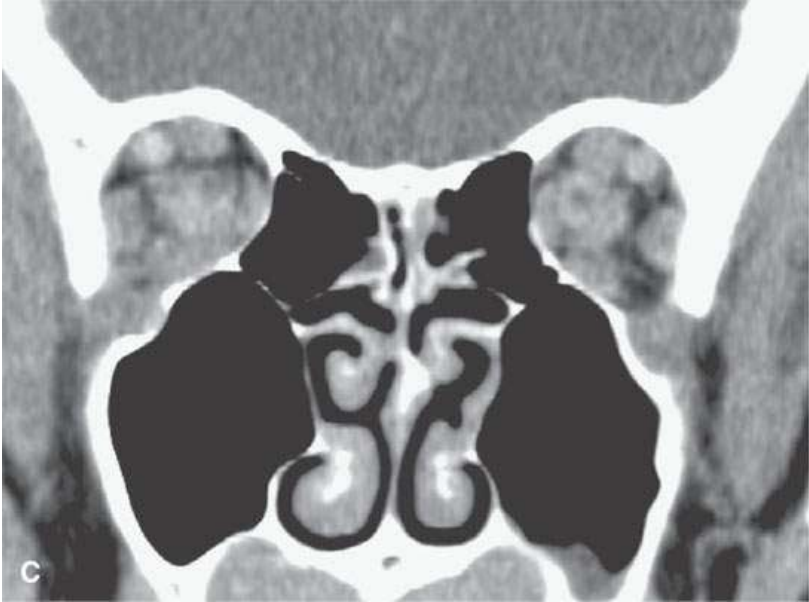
Contrast-enhanced computed tomography showing a minimally enhancing multifocal, bilateral infiltrating process in the orbits (A–C), nasal cavity (B), showing avidity for perineural spread along the infraorbital nerve canals (B, C), in the pterygopalatine fossa (D), and beneath the superficial musculoaponeurotic system (E). The parotid glands are involved bilaterally as well (F).
